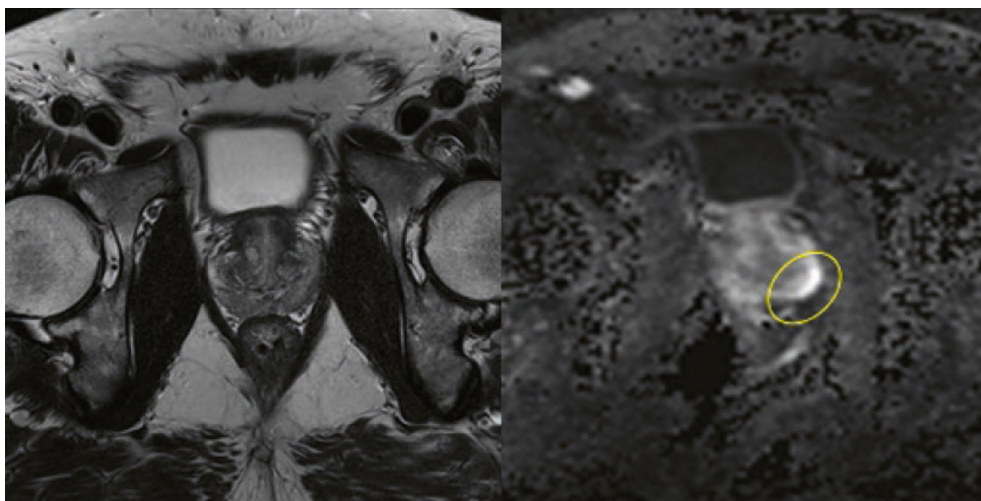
Multiparametric MRI. The left image, despite higher resolution and contrast, does not show obvious signs of disease. The same prostate is imaged with a scan sensitive to diffusion, revealing the presence of a PI-RADS 4 lesion on the left posterolateral corner (Bomers et al., 2020).
